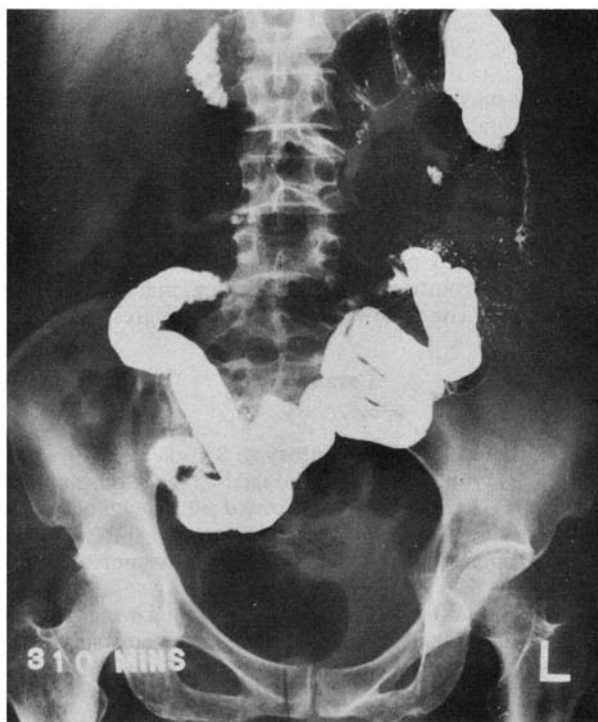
(Case 1.) Barium small bowel X-ray at 5 h shows grossly impaired small bowel peristalsis. (24 June 1968.)
